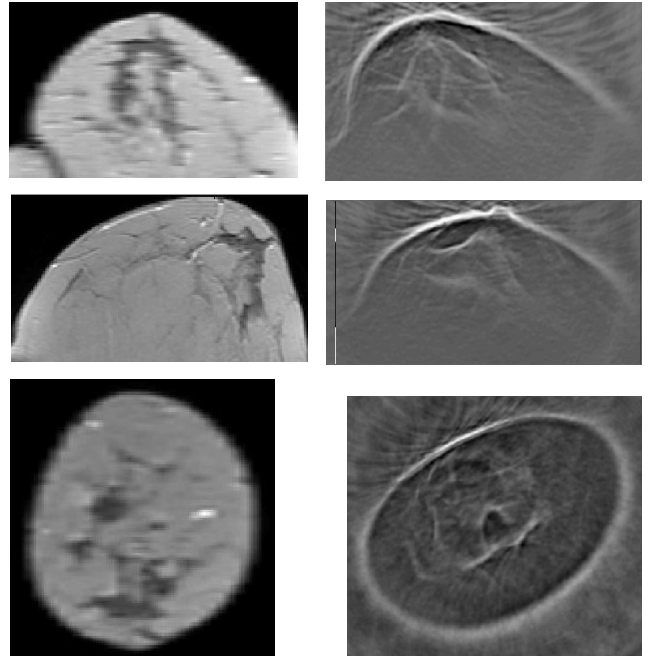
69-year-old healthy volunteer, D cup. Left: MRI slices in sagittal (top), transversal (left) and frontal (bottom) direction. Right: USCT slices at similar positions.
